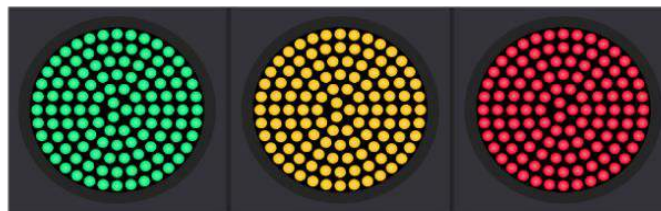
Abbreviations | CTCA: CT Coronary angiogram, CCU: Coronary Care Unit, ICCU: Intermediate Coronary Care Unit, MICU -Medical Intensive Care Units, SICU – Surgical Intensive Care Unit, ICU – Intensive Care Unit, A&E – Accident and Emergency, ED – Emergency Department, ETU- Emergency Treatment Unit, PCU – Preliminary Care Unit, OPD - Outpatient Patient Department
